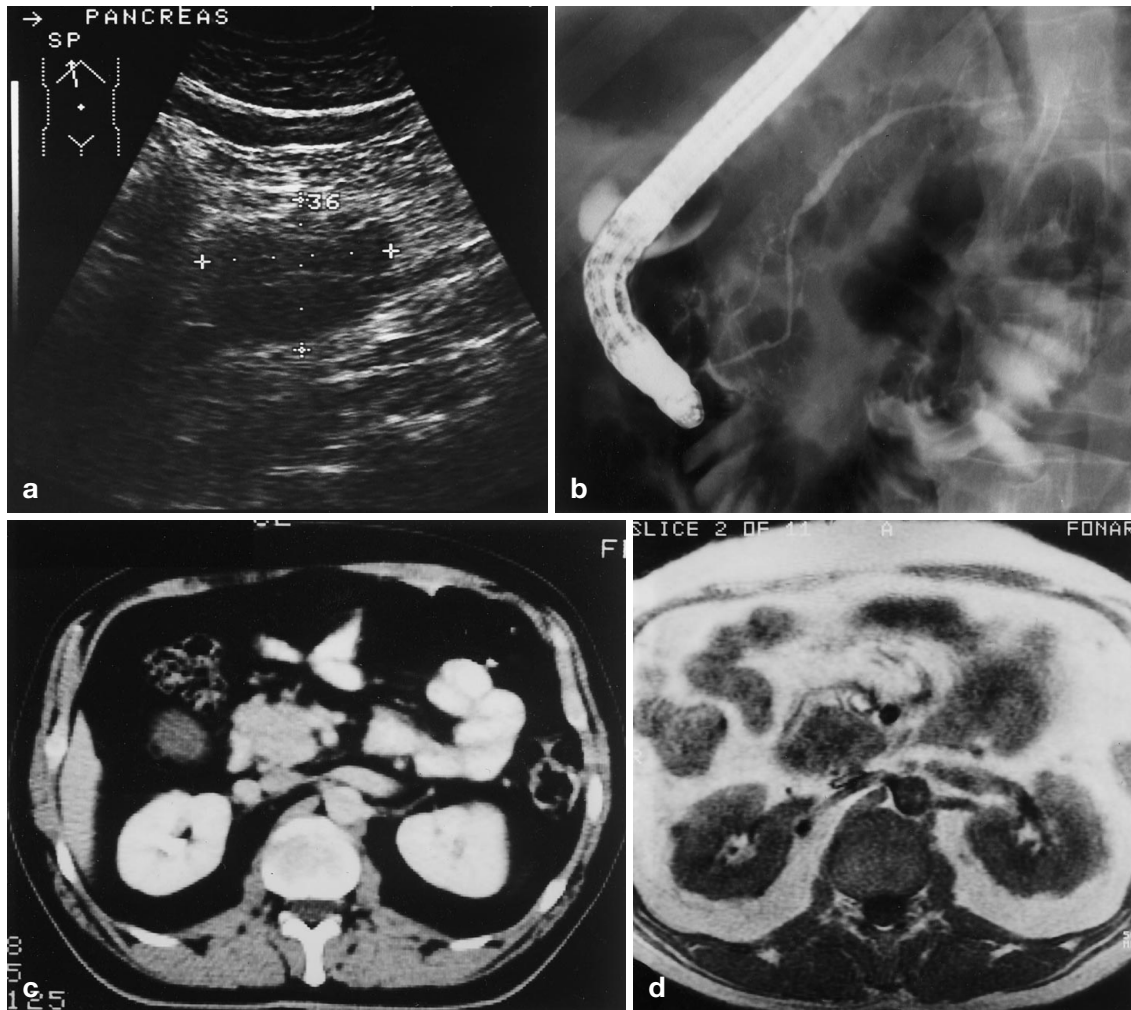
Same as Fig. 3, but in a 45-year-old male. Percutaneous ultrasound-guided biopsy was performed in both patients, and cytology revealed inflammatory reaction
